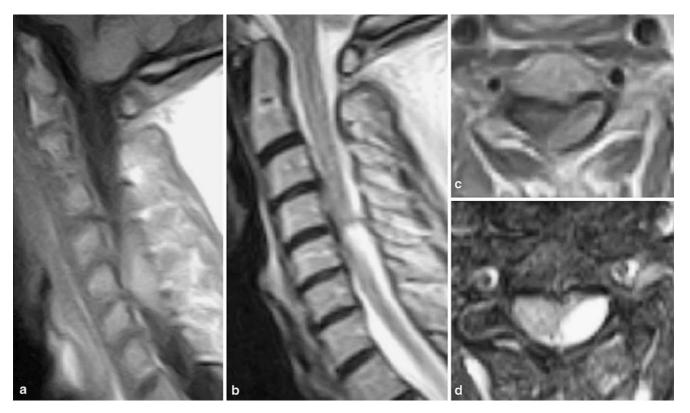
MRI 2 days after the onset of symptoms. Posterolateral placement of the haematoma at C4–C5 level. a, c Isointense appearance of the haematoma on the MRI T1-weighted sagittal
